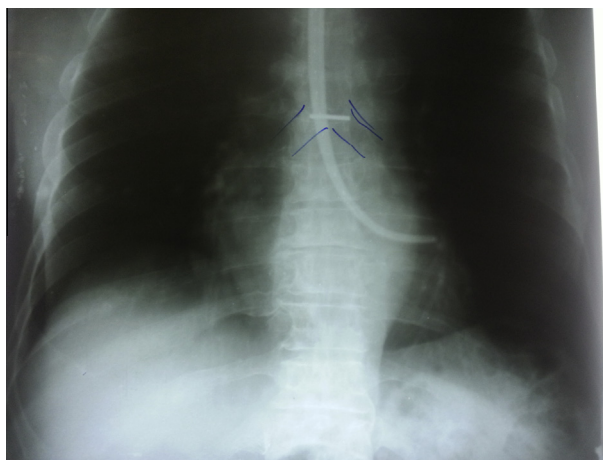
Postero-anterior projection chest X-ray of the patient after introducing the brachytherapy catheter (opaque object). The location of the tracheal bifurcation is highlighted in blue.
